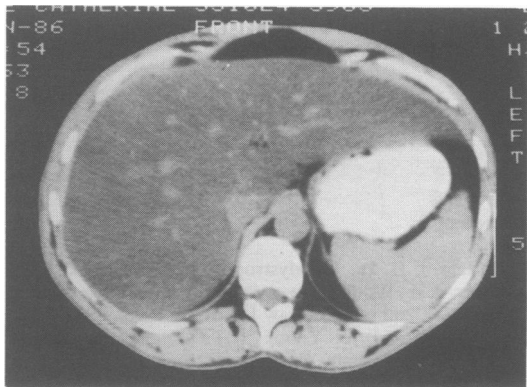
CT scan at presentation, showing portal vessels standing out against uniform low density of surrounding liver.
